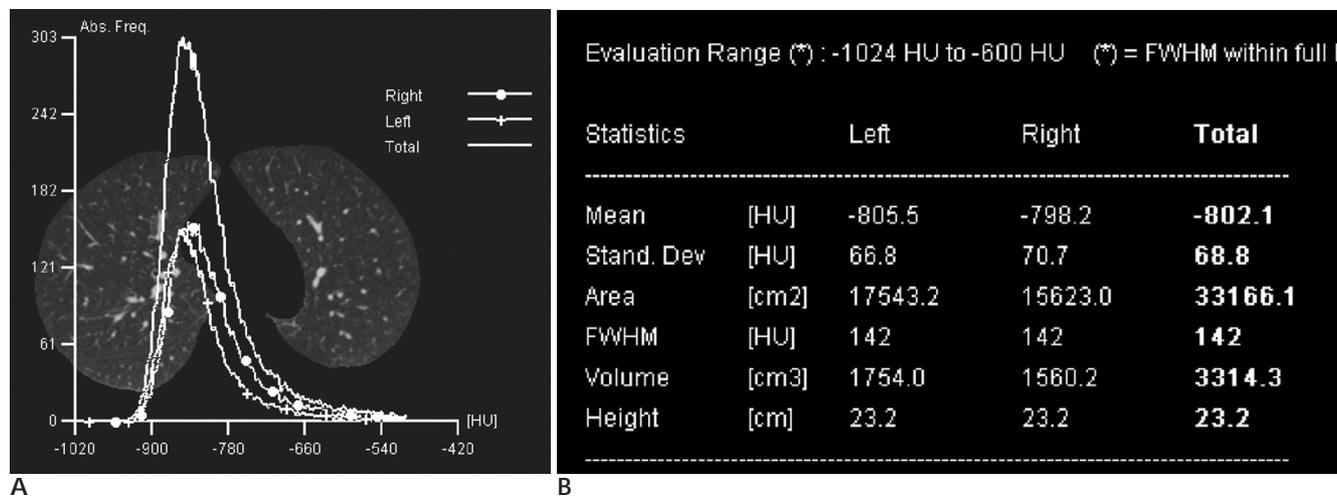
Demonstration of pulmo-CT results with a histogram (A) and table (B).
